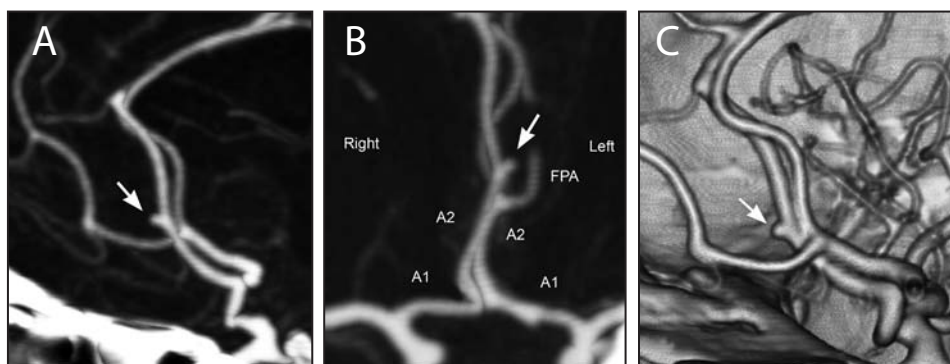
CTA images of small, unruptured A2 trunk aneurysm (arrow) as seen on (A) sagittal view, (B) axial view, (C) 3D -reconstruction.
